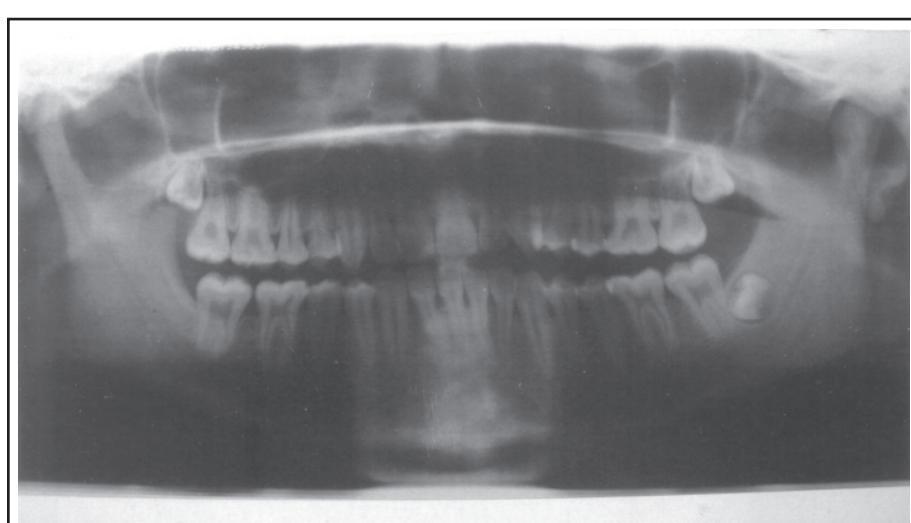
Preoperative orthopantomogram showing elongated neck of condyle on the right side.
